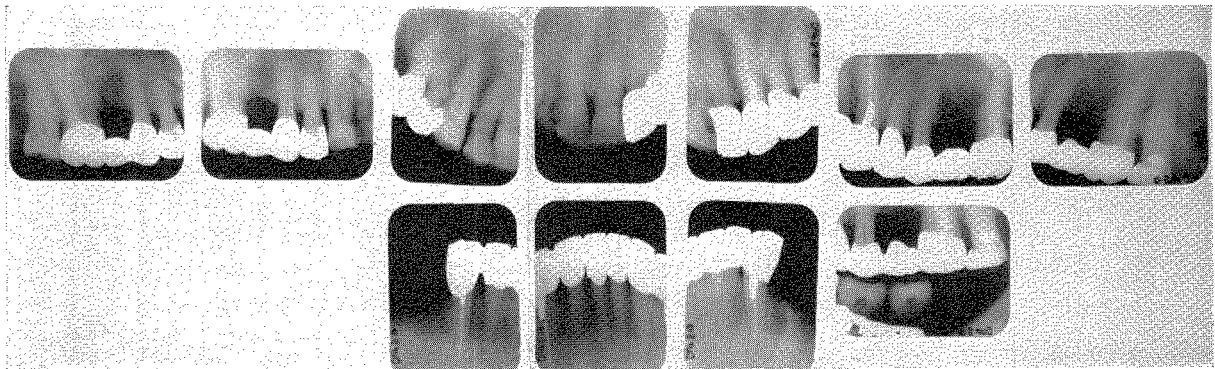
Roentgenograms taken in September, 1962.
